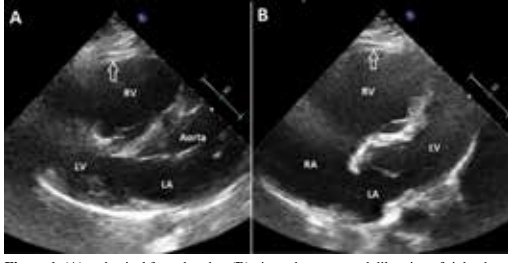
(A) and apical four chamber (B) views demonstrated dilatation of right chambers and a thin endocardial and epicardial layer of right ventricle parallel to each other (arrows) which was consistent with the absence of myocardium of right ventricle.
